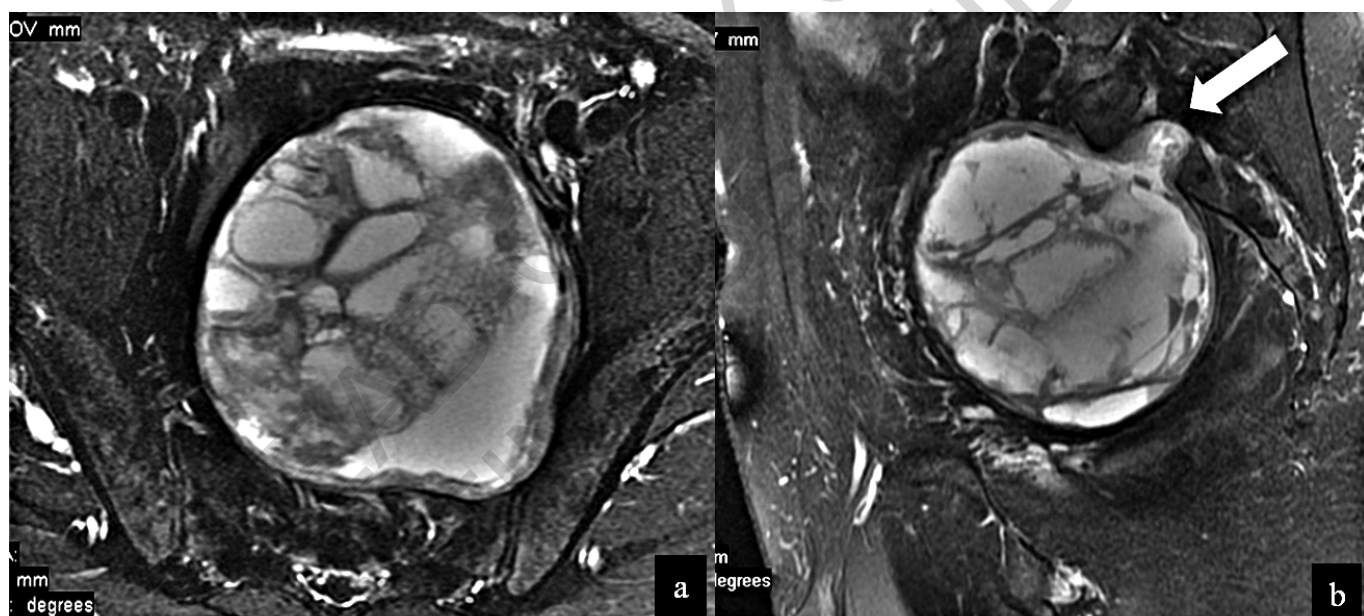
Presacral schwannoma. Axial (a) and sagittal (b) T2-weighted fat saturation MR images show a huge well-defined heterogeneous solid lesion of mixed-signal intensity in the pelvis, arising from the sacrum with foraminal extension of the mass (arrow in b).
